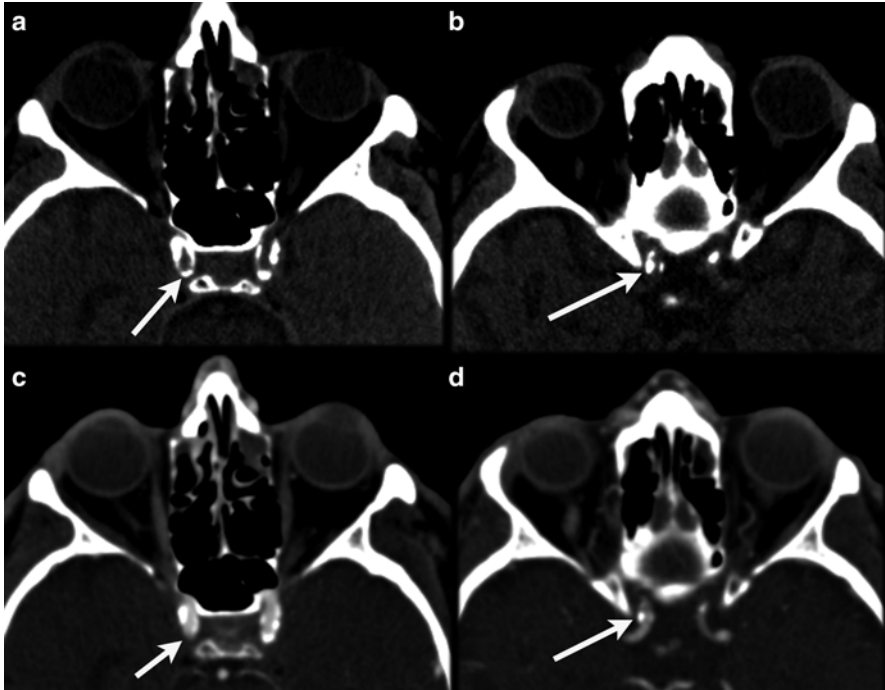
Intracranial calcifications are better depicted on thin slice NECT images (a and b), compared to CTA source images (c and d) due to identical HU of iodine and calcifications
